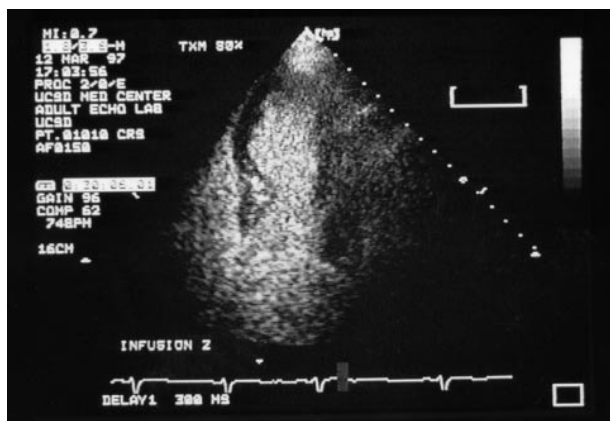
In this example, a patient with acute anterior myocardial infarction has been studied by contrast echocardiography. The contrast agent was intravenously injected, 48 hours after successful reperfusion of the infarct-related artery by percutaneous coronary angioplasty. The contrast filled the left ventricular cavity and perfused the basal interventricular septum and the lateral wall. A clear perfusion defect was observed in the mid-apical part of the septum, indicating extensive post-infarct damage.
